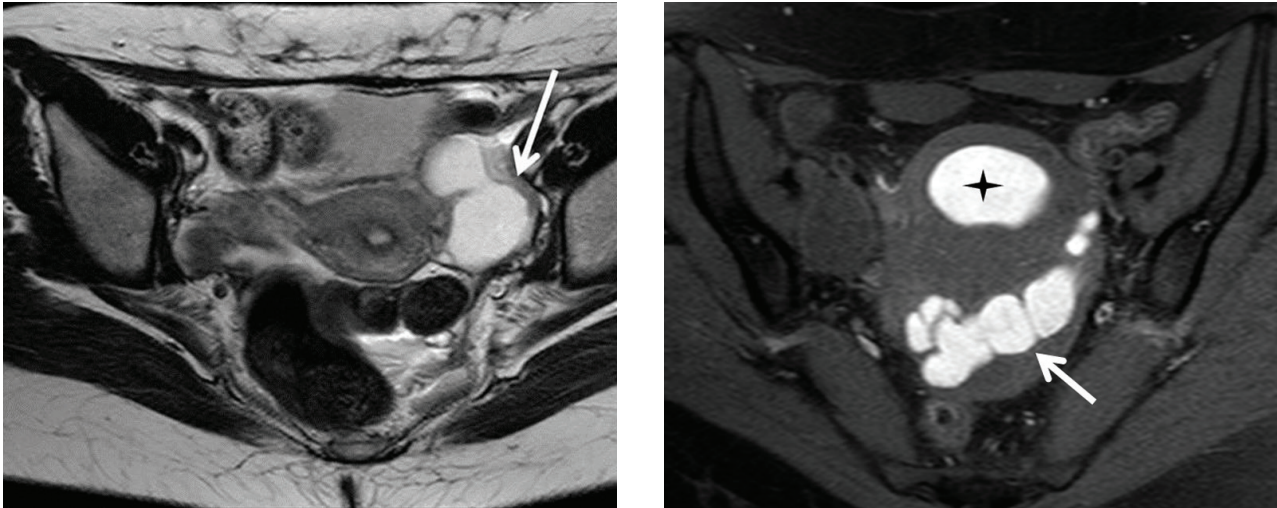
Axial T2W MR image (TR/TE: 3500/90) of a 29-year-old asymptomatic woman 6 months post ART (a). Note left hydrosalpinx (arrow). (b) Axial T1 fat-suppressed (SPIR) image (TR/TE: 400/20) of a 34-year-old post ART patient shows the presence of hematosalpinx on the left side of the pelvis (arrow). Hematometra is also evident due to severe isthmic stenosis (asterisk)
